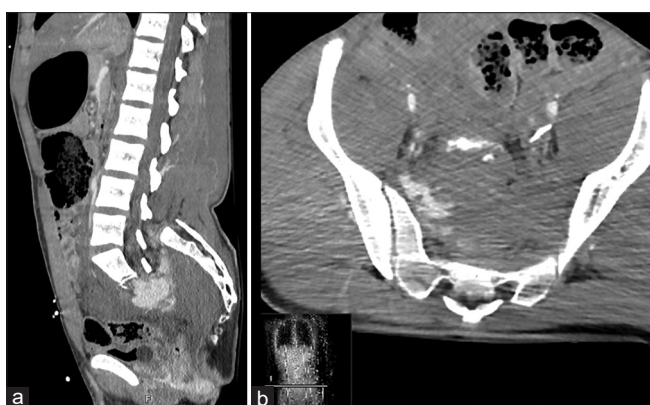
Sagittal (a) and axial (b) lumbosacral angio-computed tomography scan documenting a sacral Type 3C Roy-Camille fracture with spinopelvic dissociation, responsible for vascular lesions that caused massive bleeding
